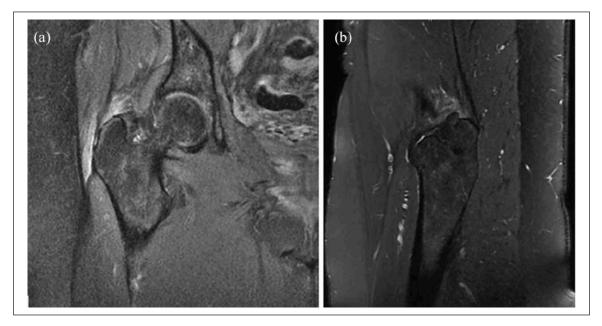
(a) Coronal fat suppressed proton density and (b) sagittal T2-weighted sequences on MRI of the right hip showing a highgrade partial tear of the gluteus medius and minimus tendons with tendinosis and underlying trochanteric bursitis. The patient consented for publication of this imaging.
